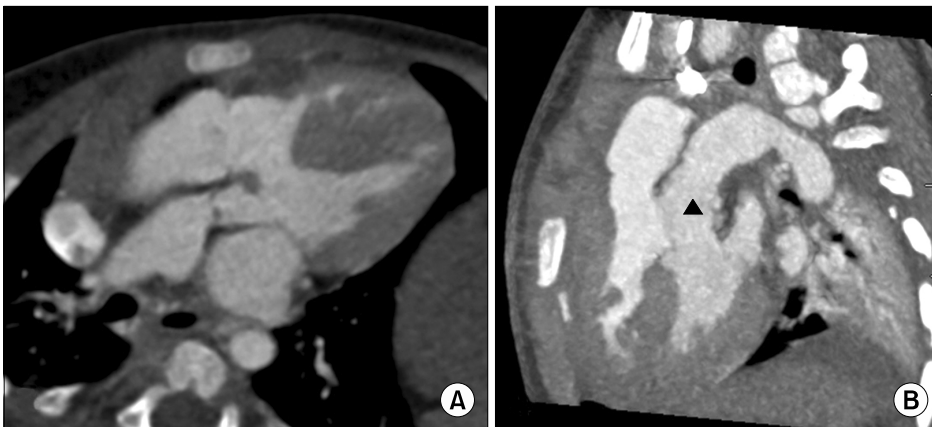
Case 2: transposition of the great arteries with ventricular septal defect and pulmonary stenosis. (A) Preoperative CT. (B) Postoperative CT showing a widened and straightened left ventricle outflow tract (▲). CT, computed tomography.
